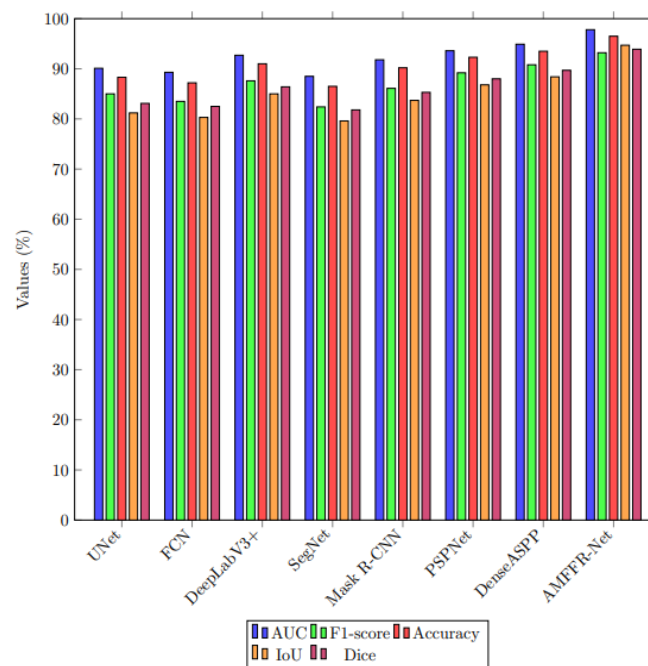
Performance analysis plot for Ultrasound dataset.
